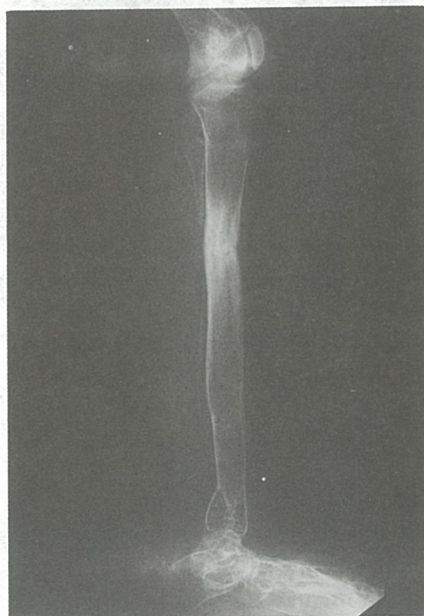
C and D The radiograph after removal of the frame, consolidation at the pseudarthrosis site was obtained but there was mild collapse at the lengthening site.
